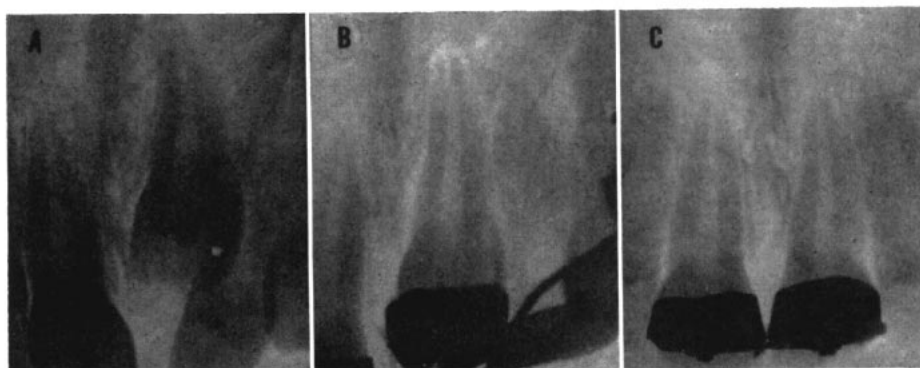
X-rays of case I seen in Fig. 4. A, before treatment; B, casting cemented; C, at retention. Treatment time was fourteen months.
